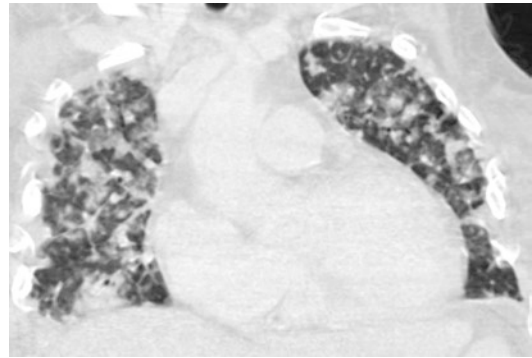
Bronchopneumonia. CT coronal scan demonstrates multiple, bilateral, centrilobular nodules
